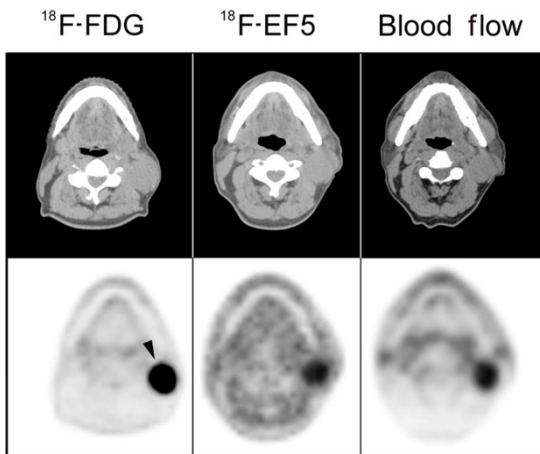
Examples of both PET and CT images for all three tracers for three patients. [^{18}F]EF5 images are obtained at 3 hours post injection. Arrow indicates the primary tumour (Figure adopted from publication I).
